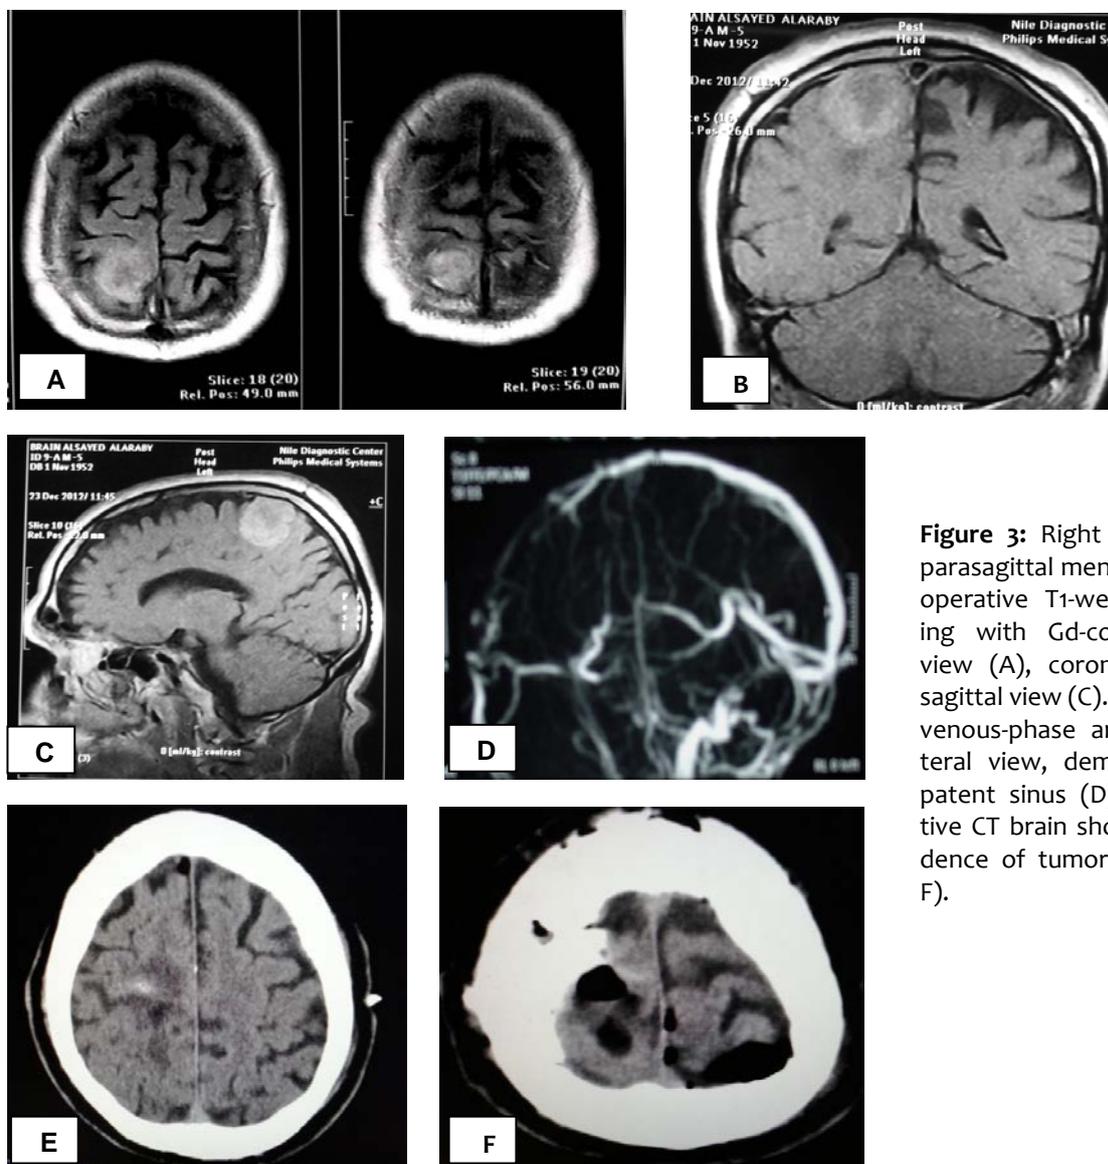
Right middle third parasagittal meningioma. Pre-operative T1-weighted imaging with Gd-contrast; axial view (A), coronal view (B), sagittal view (C). Preoperative venous-phase angiogram, lateral view, demonstrating a patent sinus (D). Postoperative CT brain showing no evidence of tumor remnant (E-F).
